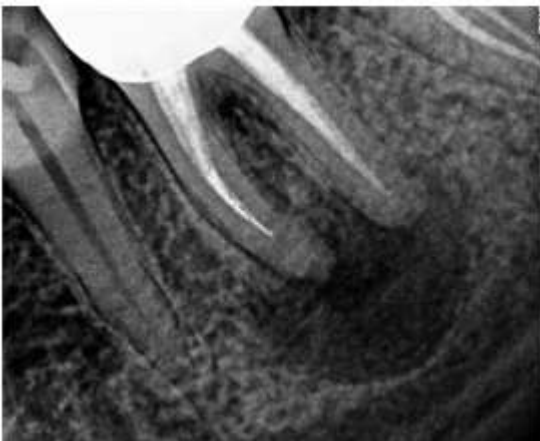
Preoperative Radiograph Showing Periapical Radiolucency #36
